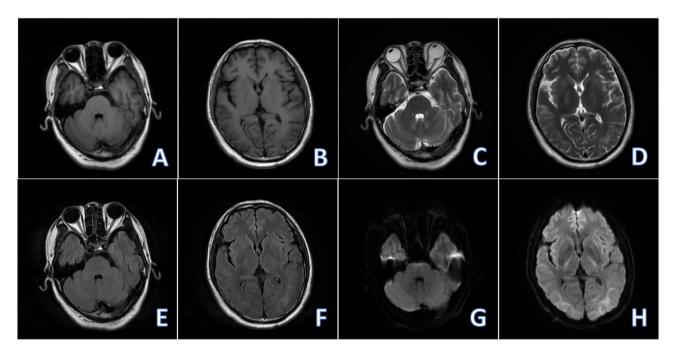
Non-contrast brain MRI (at 164 days post-admission). (A-H) The range of abnormal signals in the brain has decreased compared to (at 15 days post-admission), and the DWI signal of the lesion tends to be normal, with no new lesions observed. MRI, magnetic resonance imaging; DWI, diffusion-weighted imaging.
